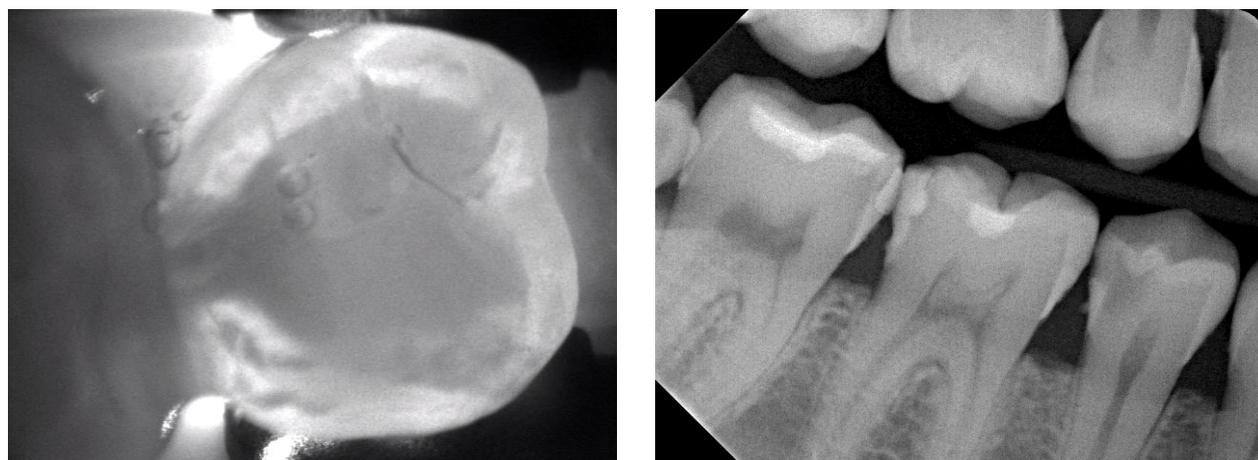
At the distal surface of tooth # 45, the DIAGNOcam image shows lower dentine translucency compared to the dentine not affected by the caries. The carious process has involved the dental enamel and has progressed into the inner half of the dentine. The associated bitewing X-ray image points to a carious process also reaching into the inner half of the dentine.
